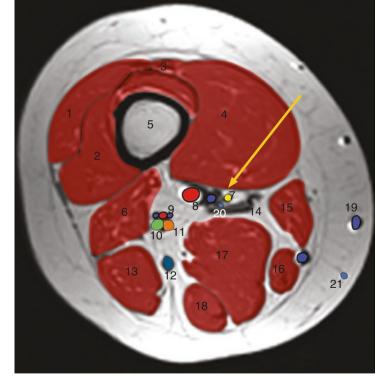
MRI scans at the proximal third of the thigh through the femoral nerve
